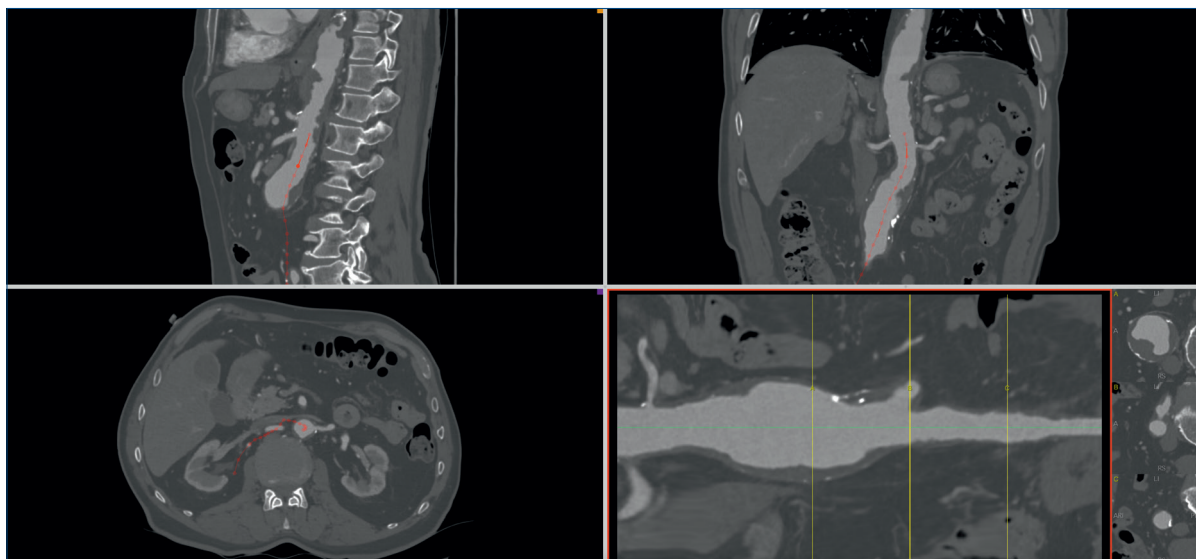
• Multiplanar and center-lumen-line virtual reconstruction of a preoperative CTA planning an abdominal aortic aneurysm intervention.
